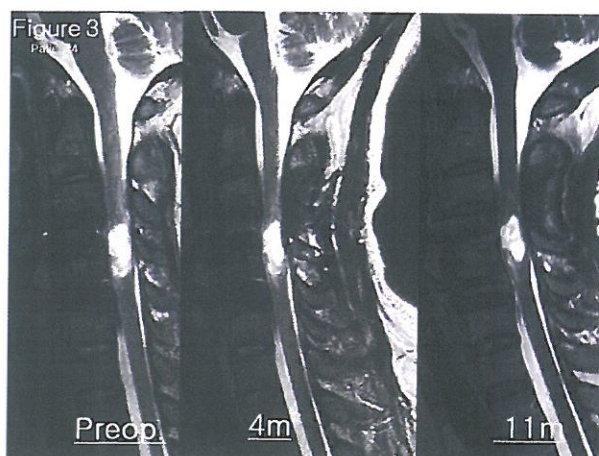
In Patient 4, decrease of cavity size and change of cavity shape was shown in T2 weighted image of the follow-up MRI.
